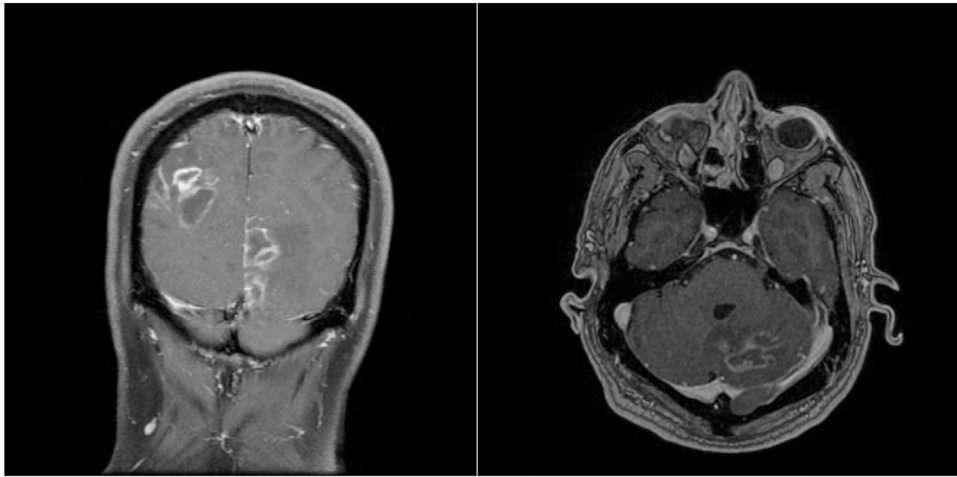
Multiple diffuse contrast enhancing lesions with central cavitation. Large lesion in the right occipital lobe and left cerebellum on T1 MRI.
